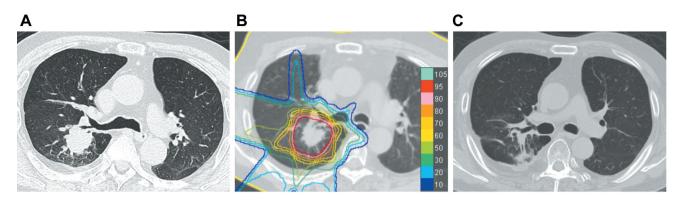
Example of a treated case. (A) Computed tomography at pretreatment diagnosis. (B) Dose distribution of proton beam therapy. (C) Twentyfour months after proton beam therapy.
